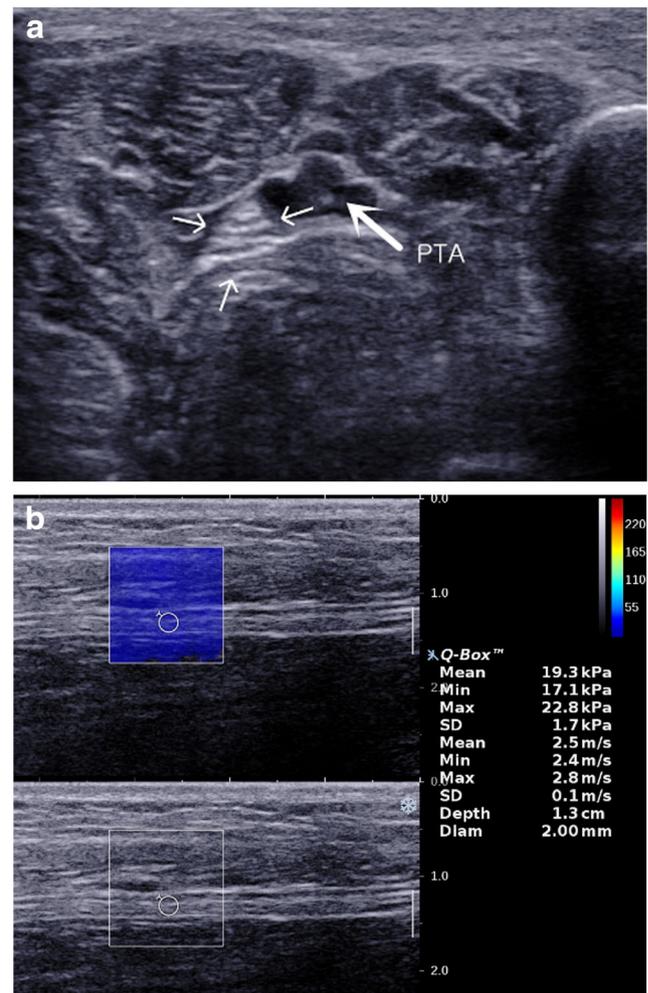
a Transverse ultrasonography of the tibial nerve (thin arrow) 4 cm proximal to medial malleolar level in a 42-year-old male diabetic patient with DPN. PTA, posterior tibial artery. b Longitudinal split images of tibial nerve (between arrows) 4 cm proximal to medial malleolar levels in a 63-year-old male diabetic patient without DPN. Lower image is a longitudinal ultrasonography of tibial nerve with superimposed color box borders for SWE map and circular ROI for quantitative measurements on upper image. The E_{Mean} , E_{Min} , and E_{Max} elasticity indices are measured as 19.3, 17.1, and 22.8 kPa, respectively
